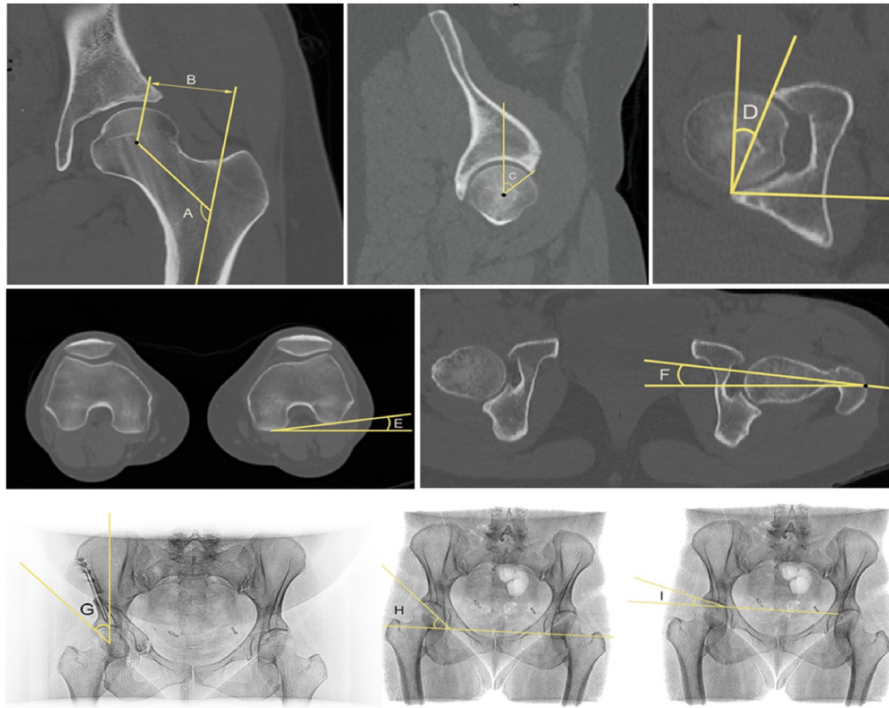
Radiographic measurements on CT (A–F) and generated x-ray (G–I).
